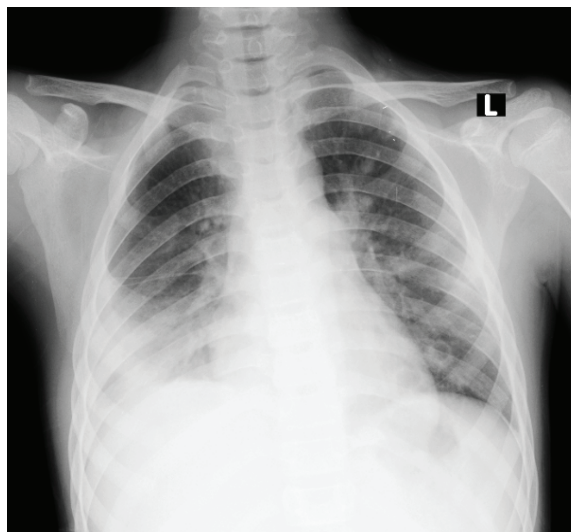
B: Chest x-ray three days after admission showing progressive right lower lobe infiltrate
